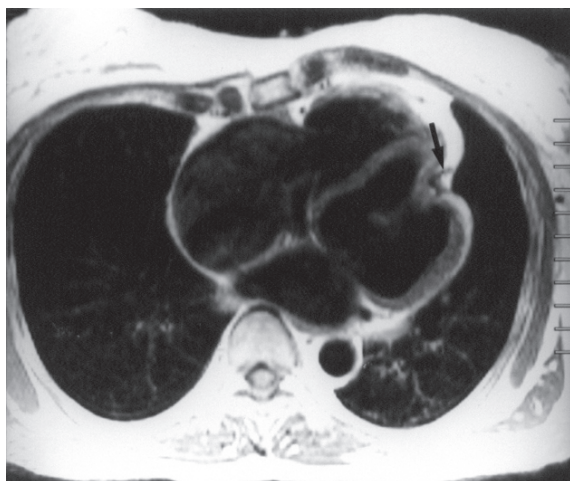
Axial T1-weighted breath-hold MRI of thorax showing localised pericardial thickening (arrow) at the site where the left ventricle is inwardly indented. Enlargement of both atria, particularly of the right, are present.
